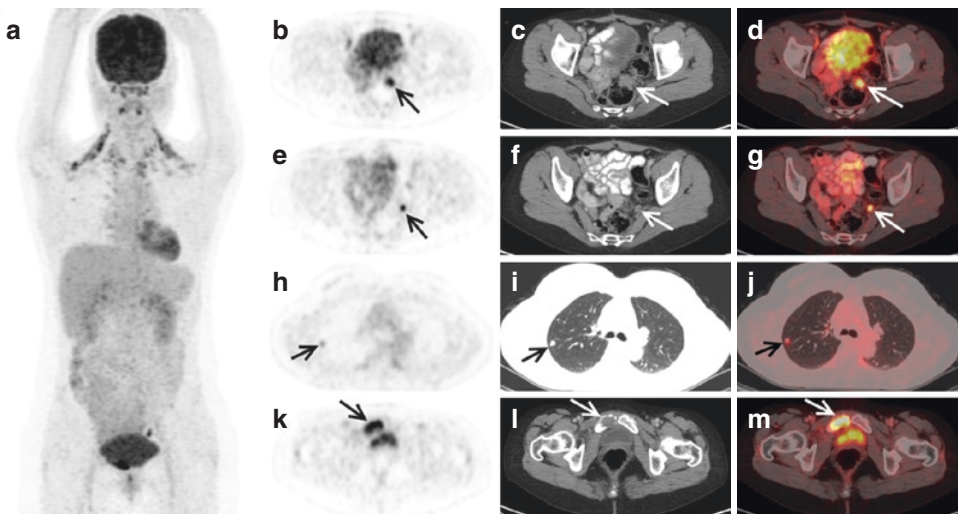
FDG PET/CT after primary treatment in a known case of ovarian carcinoma post radical surgery and adjuvant chemotherapy. There is FDG-avid pre-sacral serosal soft-tissue deposit abutting sigmoid colon highlighted with arrows in the MIP (a) axial and corresponding sagittal PET, CT, and fused PET/CT images (b–g). In
